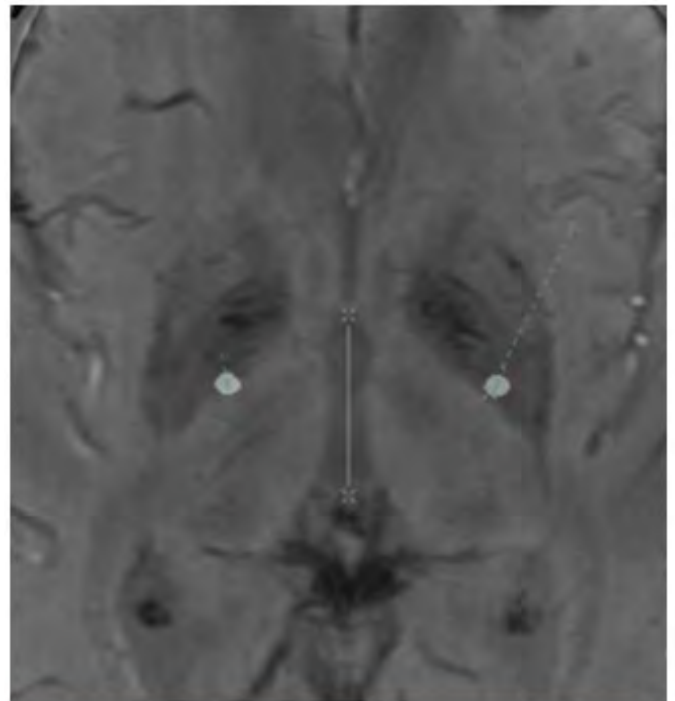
Post-operative fusion of the MRI and CT scans showing adequate placement of the DBS electrodes within the GPi on axial imaging sequences.
